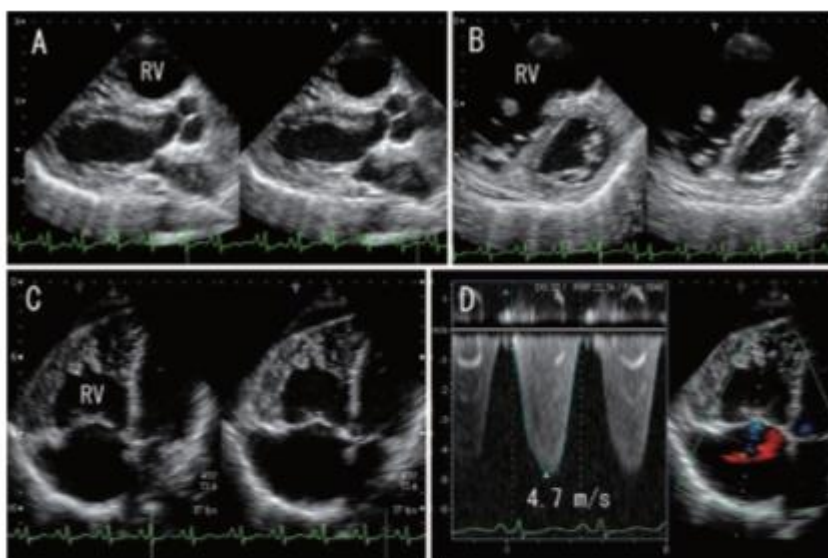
Echocardiography showing features of Pulmonary Hypertension: The figure above depicts the features which can be seen on Echocardiography in cases of Pulmonary Hypertension. Panels A. show marked right ventricular dilatation (left: end-diastole, right: end-systole). Panel B demonstrates flat interventricular septum in the cross-sectional view, and Panel C demonstrates hypertrophied right ventricular free wall in the apical four chamber view. Panel D shows that the peak velocity of tricuspid regurgitation is 4.7 m/s, suggesting an estimated right ventricular systolic pressure of 98.4 mmHg(50).
